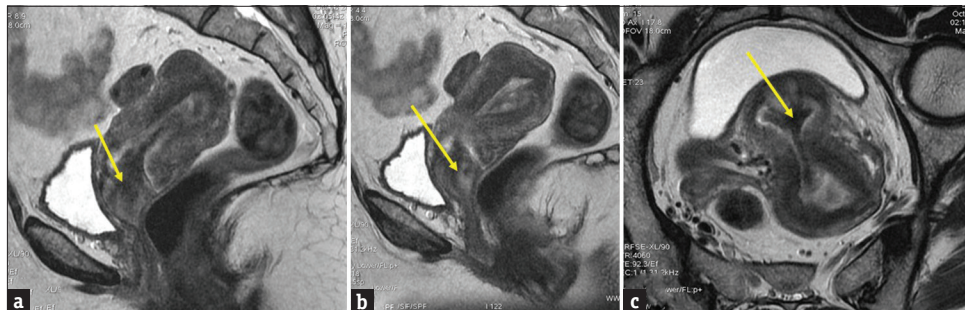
A 49-year-old female presenting with pain and PV bleeding with endometrial polypoidal SOL: Sagittal (a and b) and Coronal T2-weighted images (c) through uterine axis reveal a long narrow pedicle from the fundus, leading to 3.8-cm sized polypoid lesion (yellow arrow) coursing through the endometrial cavity and distending cervical canal, with low signal intensity (SI) on T2, diffusion-weighted image low signal with low apparent diffusion coefficient values (T2 Dark Phenomena)
